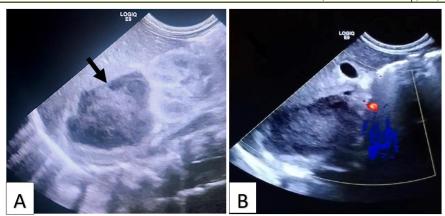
Ultrasound of the abdomen demonstrating a heterogeneous right suprarenal mass, predominantly hypoechoic with internal echoes (A) with no internal vascularity on Doppler (B), consistent with adrenal hemorrhage
